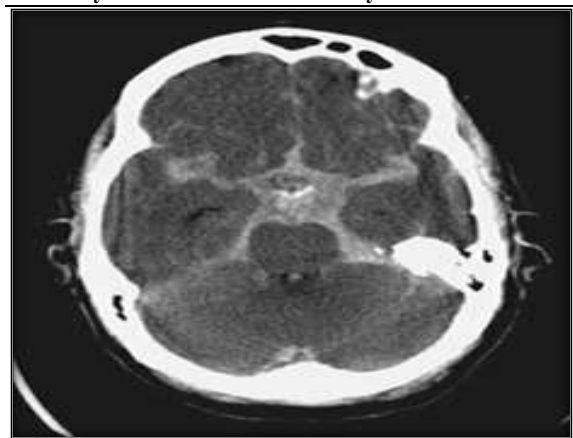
Axial non-contrast CT brain demonstrating hyperdense blood within the basal cisterns and bilateral Sylvian fissures, producing the characteristic "star sign" (arrow), consistent with subarachnoid hemorrhage.
